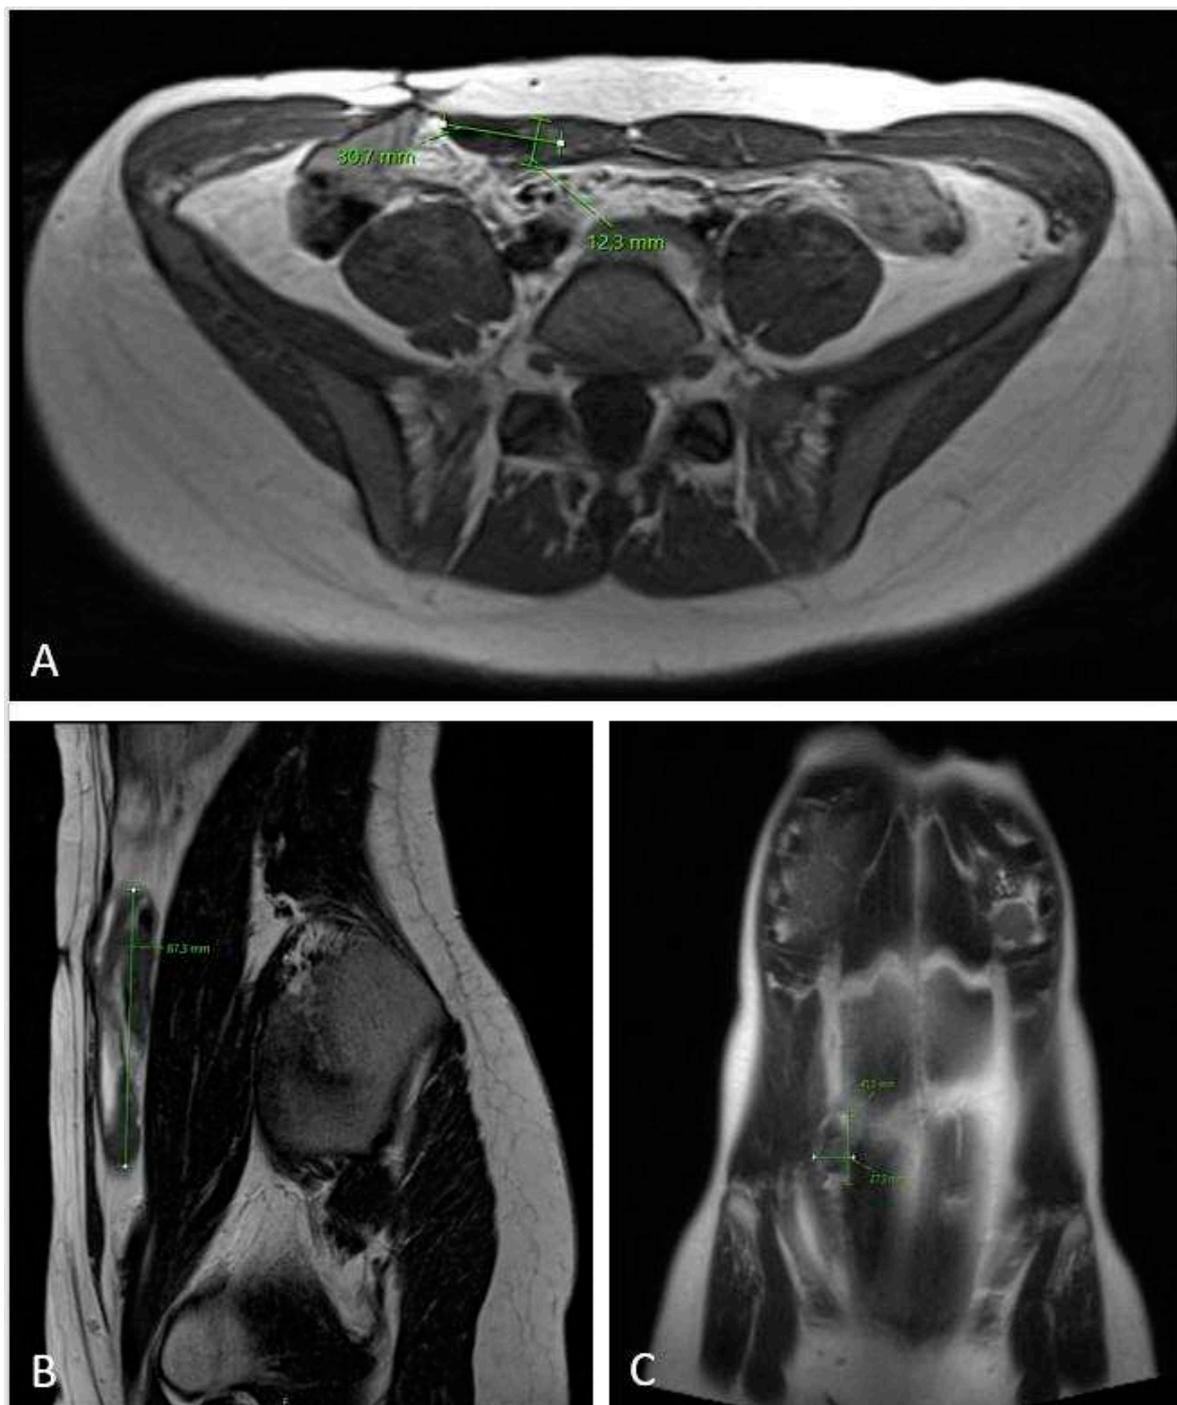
MRI scan (A – axial plane; B – sagittal plane; C – coronal plane) 12 months after chemotherapy showing significant tumor regress, sized only 1.2 x 3.7 x 8.7 cm.
